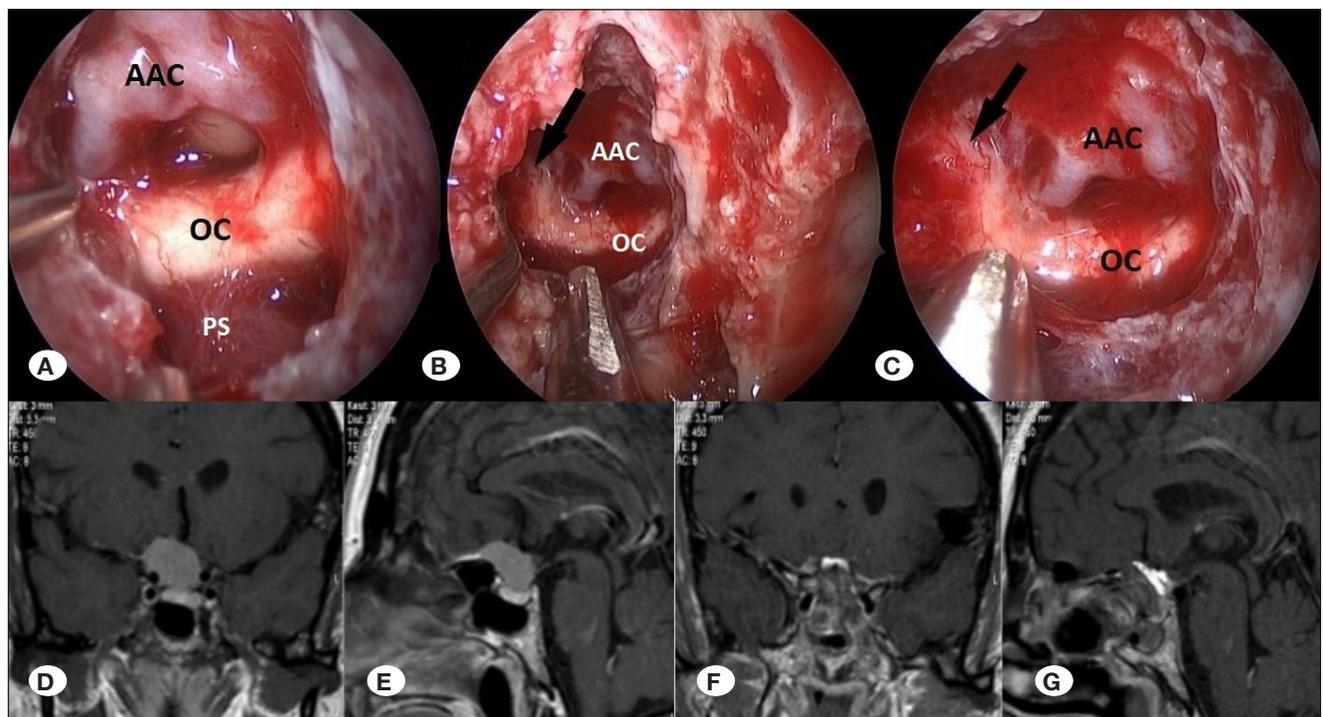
A) Evacuation of the optic canal invasion part of the tumor B) Evacuation of the optic canal inferomedial invasion. Black arrow indicates right optic nerve C) After evacuation of the optic canal invasion part of the tumor. Right optic nerve appears crushed (black arrow) D) Preoperative coronal T1-contrast-enhanced MR image of same patient E) Preoperative sagittal T1-contrast-enhanced MR image of same patient F) Postoperative coronal T1-contrast-enhanced MR image of same patient G) Postoperative sagittal T1-contrast-enhanced MR image of same patient. OC: Optic chiasm, AAC: Anterior artery complex, PS: Pituitary stalk.
